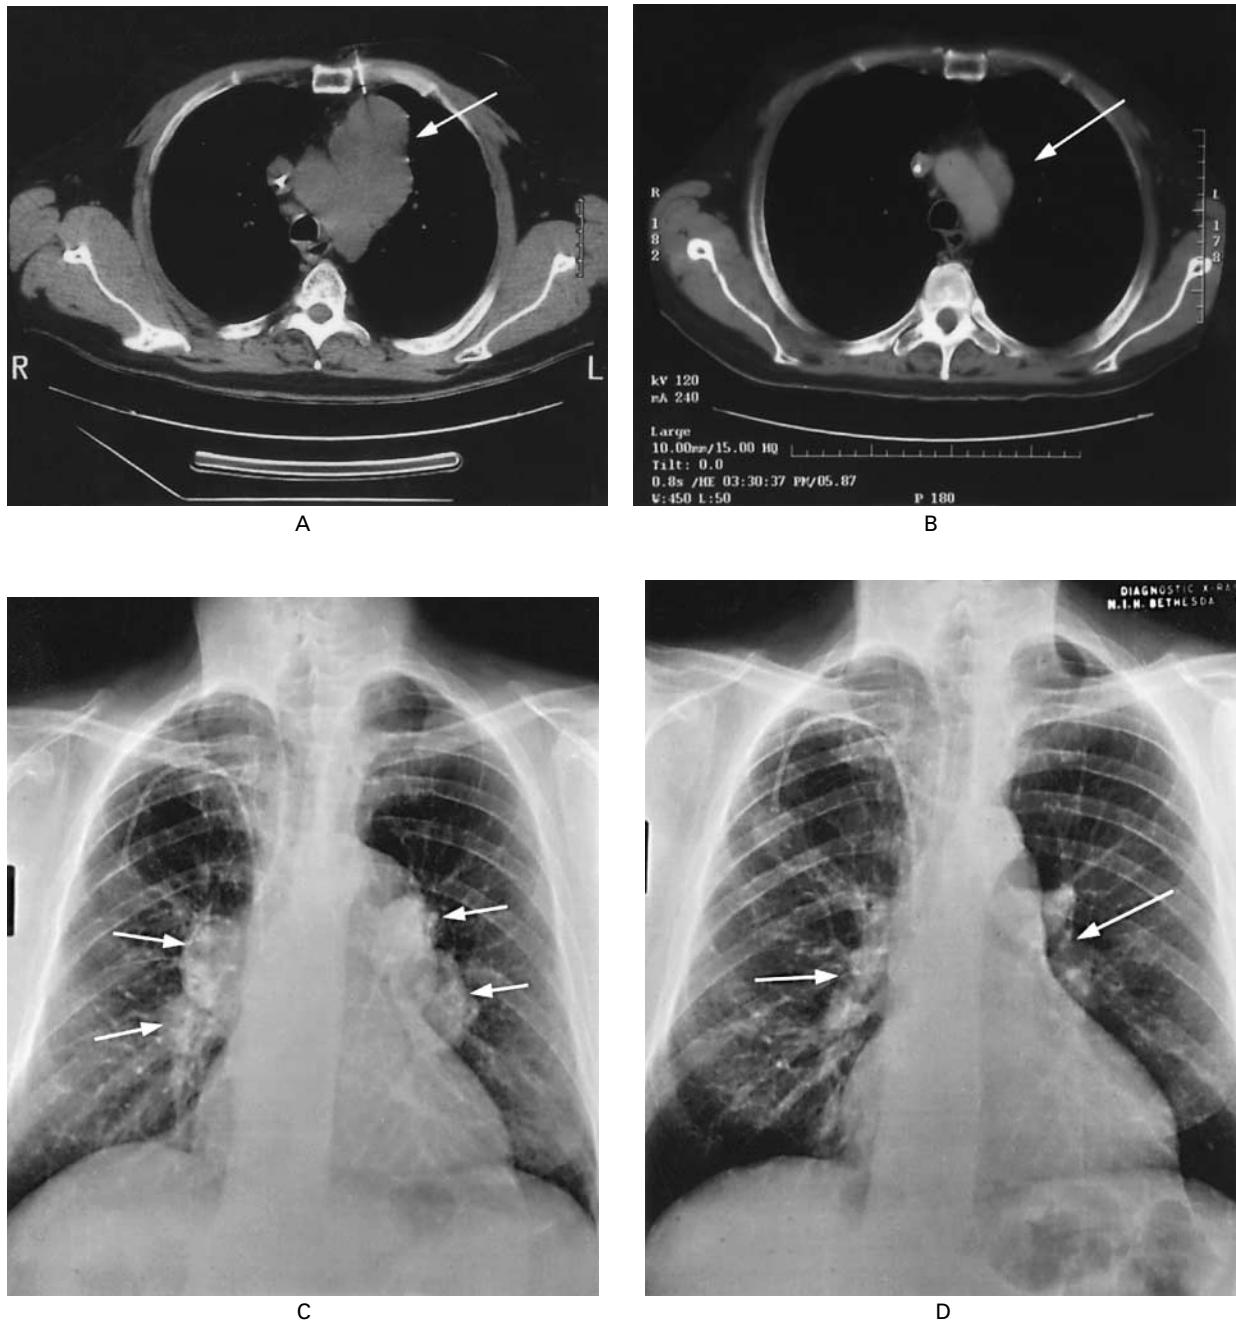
CT and Radiographic Images of Mediastinal and Hilar Adenopathy (Arrows) in Patient 8 before Transplantation (Panels A and C) and 276 Days after Transplantation (Panels B and D).
